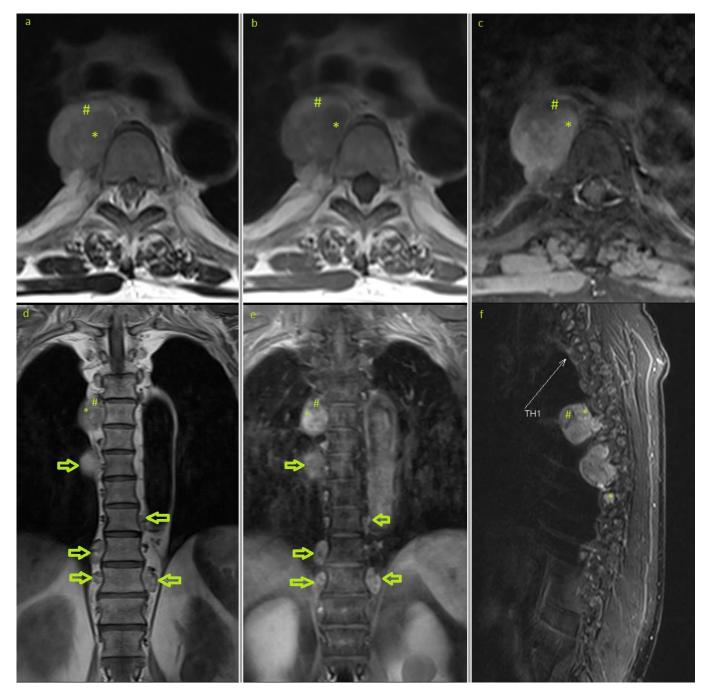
70-year-old male with bilateral multifocal paravertebral extra-adrenal myelolipoma. MRI of the thoracic spine showing a right paravertebral mass with mixed signal intensity, partially hyperintense on T2 (a) and T1WI (b) due to the fat content of the mass (#) which shows signal drop-out on the fat suppression images (c & e) and on STIR sequence (f), and partially isointense on T2 (a) and hypointense on T1WI (b) due to the myeloid component (*) which shows hyperintensity on STIR (f), and moderate enhancement (c & e). Other similar lesions (arrows) are shown on the coronal plane (d). (Technique: 1.0 T scanner. a) axial T2WI: TR/TE: 3990/105, slice thickness 8, spacing 11.20, acquisition matrix: 256x205. b) axial T1WI: TR/TE: 509/11, slice thickness: 8, spacing 11.20, acquisition matric: 256x205. c) axial contrast enhanced T1WI with fat suppression: TR/TE: 742/12, slice thickness: 8, spacing: 11.20, acquisition matrix: 256x205. Administration of 15ml gadolinium based contrast agent. d) coronal non-enhanced T1WI: TR/TE: 863/13, slice thickness: 6, spacing 7.20, acquisition matrix: 187x512. e) coronal contrast enhanced T1WI with fat suppression: TR/TE: 1020/11, slice thickness: 6, spacing 7.20, acquisition matrix: 205x256. f) Sagittal Short tau inversion recovery (STIR): TR/TE: 3330/63, slice thickness: 3, spacing 3.60, acquisition matrix: 256x205)
